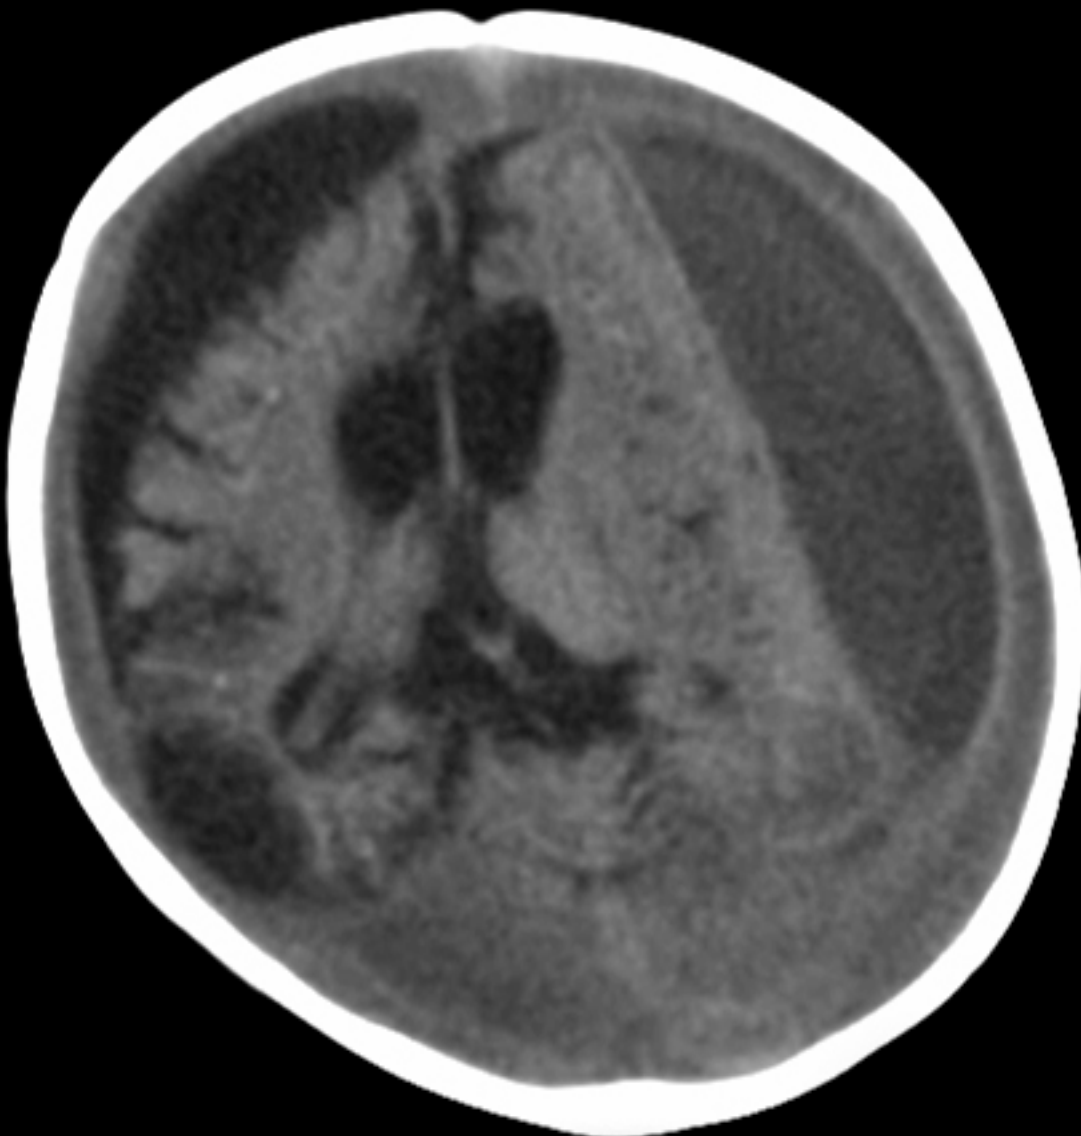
MRI depicting subdural hygromas surrounding severe brain atrophy from abusive head trauma. This child was initially erroneously diagnosed with meningitis
